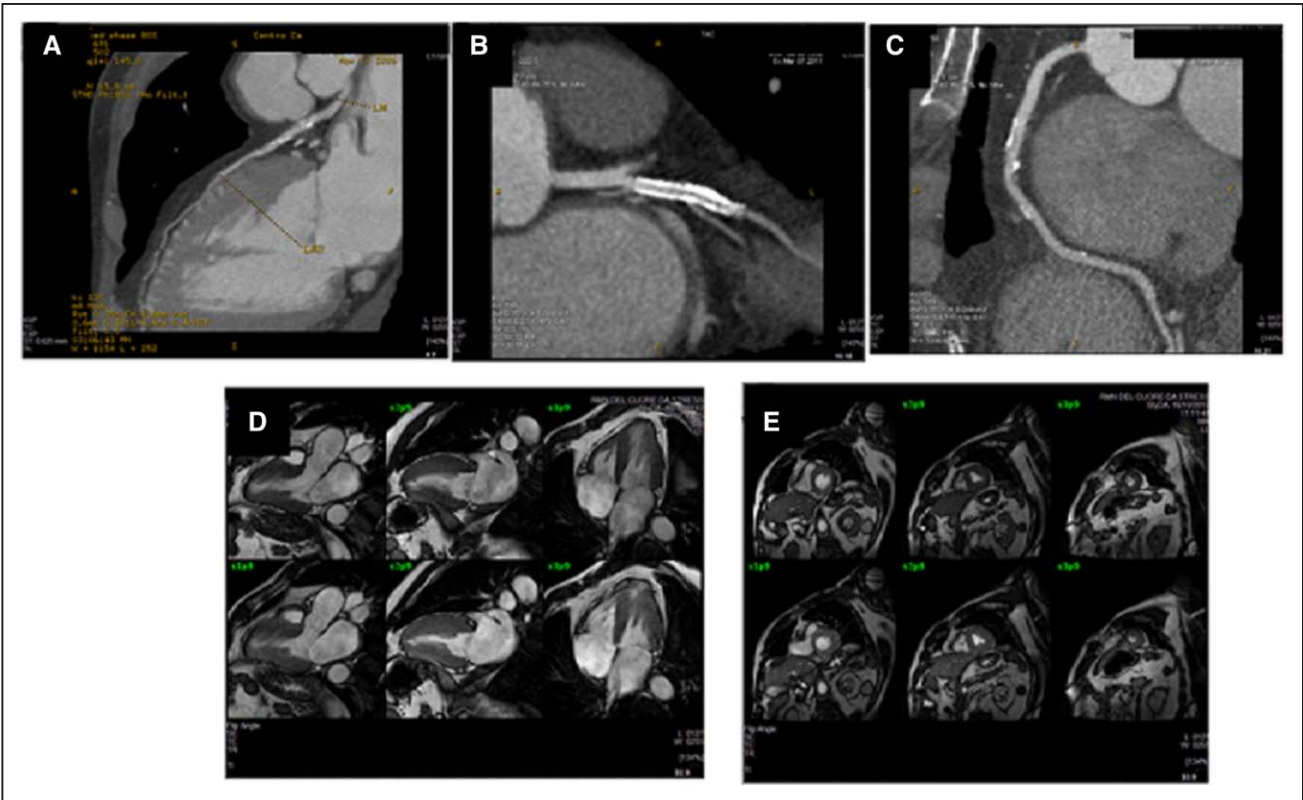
Clinical case of a 59-year-old man with history of previous myocardial infarction who underwent PCI with coronary stenting of the intermediate coronary artery. Atypical chest pain prompted cTCA as first-line test that showed 55% stenosis of proximal left anterior descending coronary artery (A), stent patency (B), and 65% stenosis of mid right coronary artery (C). Further evaluation with stress-CMR did not show any reversible perfusion defect and wall motion abnormalities (D and E). During the follow-up, no MACE occurred. CAD indicates coronary artery disease; CMR, cardiac magnetic resonance; cTCA, computed tomography coronary angiography; MACE, major adverse cardiac events; and PCI, percutaneous coronary intervention.
